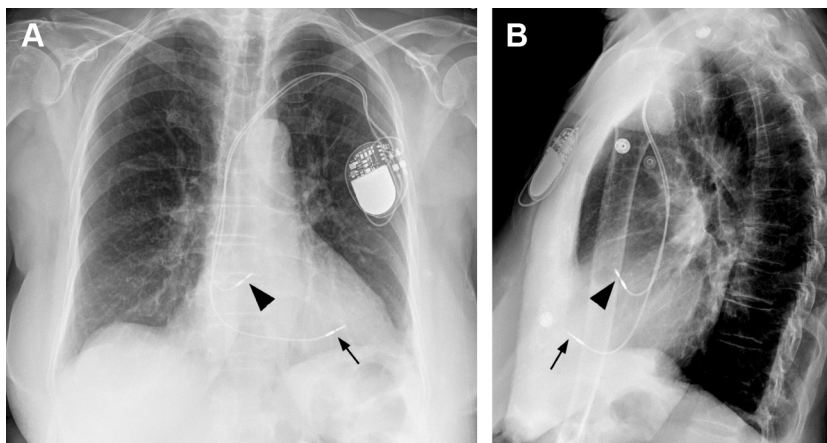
Normal appearance of a dual-lead pacemaker. (A, B) PA and lateral radiographs demonstrate a dual-lead pacemaker with pulse generator overlying the left chest wall. Pacemaker wires descend over the expected location of the SVC into the RA and RV. The atrial lead (arrowheads) typically curves upward in a “J” configuration to reside in the right atrial appendage. The ventricular lead (arrows) ideally terminates in the ventricular apex to the left of the spine.
